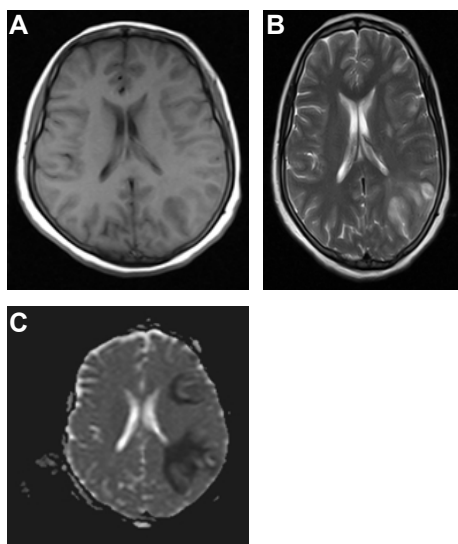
(A) Brain MRI T1. (B) Brain MRI T2. (C) Brain MRI DW.
